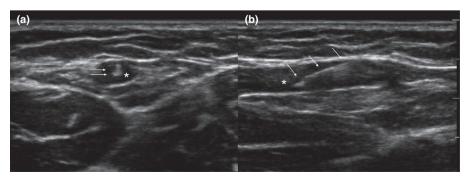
Ultrasound-guided intravenous access in a 5-year-old girl, demonstrating the needle tip (arrows along shaft) situated within a peripheral vein (\*) in both (a) short-axis and (b) long-axis views.
